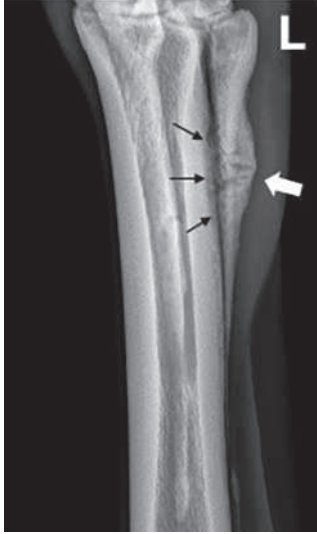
Dorsolateral-palmaromedial-oblique radiographic view of the left fourth metacarpal bone (MCIV) in case 1 (4 weeks after injury): There is focal mild soft tissue swelling with moderate smooth periosteal reactions (white arrow) involving the abaxial aspect of the proximal part of MCIV. The fracture lines are still visible in MCIV. Despite progressive fracture healing abaxially, mild irregular new bone formation with permeative lysis of the cortices of MCIII and MCIV is seen in the metacarpal interosseus space indicative of osteomyelitis (black arrows). | *Röntgenologische dorsolaterale-palmaromediale Schrägaufnahme des linken Os metacarpale IV (MCIV) des Fall 1 (4 Wochen nach der Verletzung): Es bestehen eine fokale, leichtgradige Weichteilschwellung sowie mittelgradige, ruhige periostale Reaktionen (weißer Pfeil) im abaxialen Bereich des proximalen Abschnittes des MCIV. Die Frakturlinien innerhalb des MCIV sind immer noch sichtbar. Trotz der abaxial stattfindenden progressiven Frakturheilung bestehen leichtgradige, unregelmäßige Knochenzubildungen sowie permeative Lyse im Bereich der zum Spatium metacarpeum interosseum angrenzenden Kortizes des Os metacarpale III (MCIII) und MCIV, welche auf eine Osteomyelitis hinweisen (schwarze Pfeile).*
